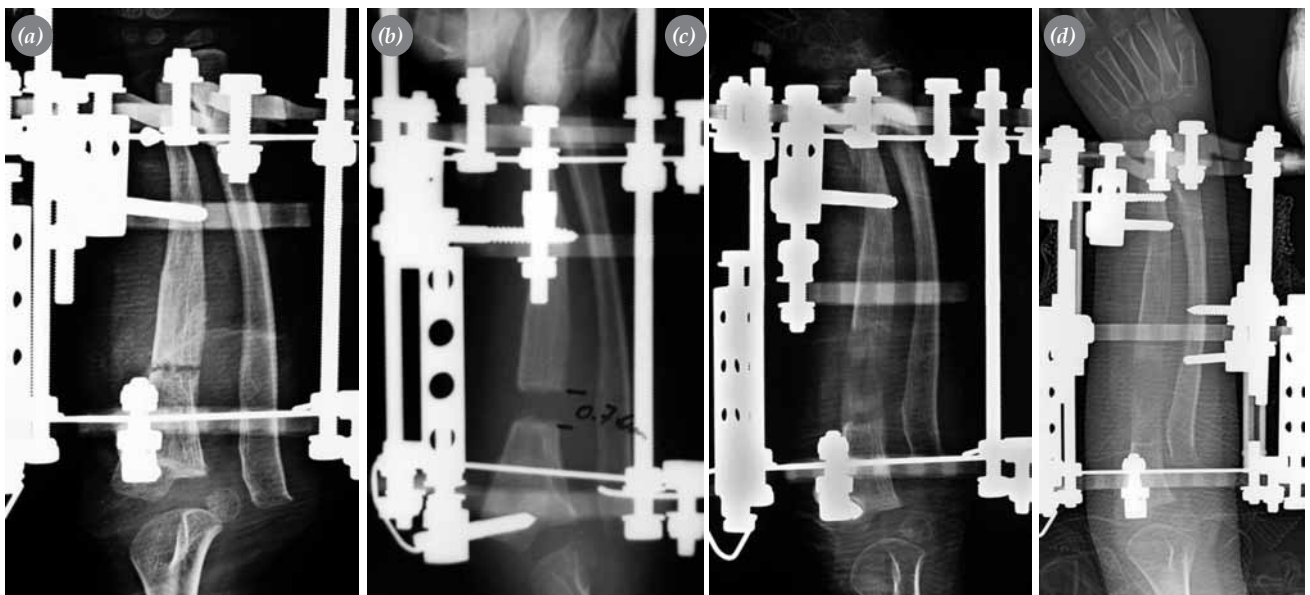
Radiographs showing (a) the ulnar osteotomy site, (b) ulnar distraction and distal sliding of the radial head, and (c) completion of radial head reduction. (d) In patient with ulnar hemimelia, the proximal radius was fixed to the frame and the ulna was lengthened further by 7 mm after achievement of radial head reduction in order to prevent future radial head dislocation due to asymmetric growth.
